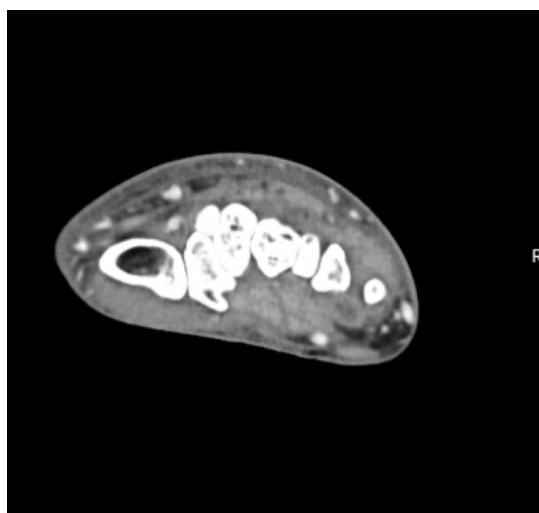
CT imaging of right wrist.
